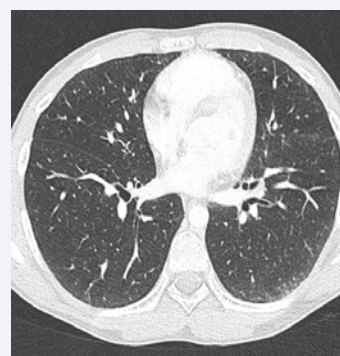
ThoraxHR-CT scan showing alveolitis with ground glass opacity of sub-pleural location with lobular reticulations and septal thickening.
